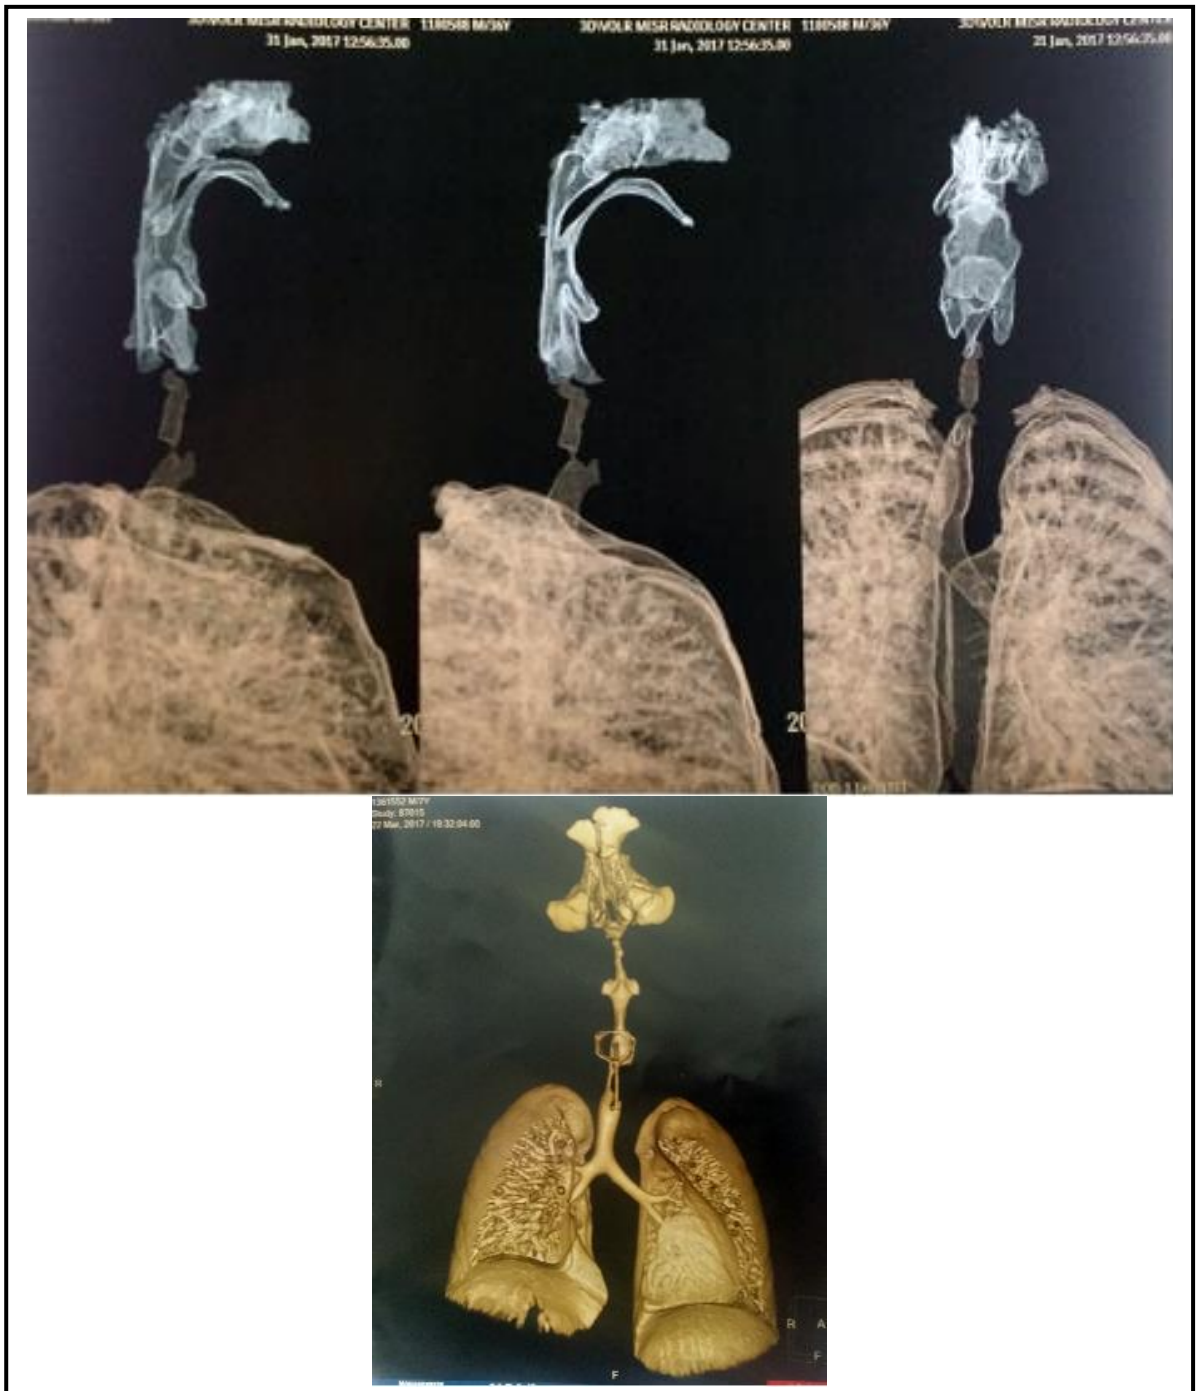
CT. slides of tracheal stenosis showing stenosed area in the subglottic upper 1/3 of the trachea.
